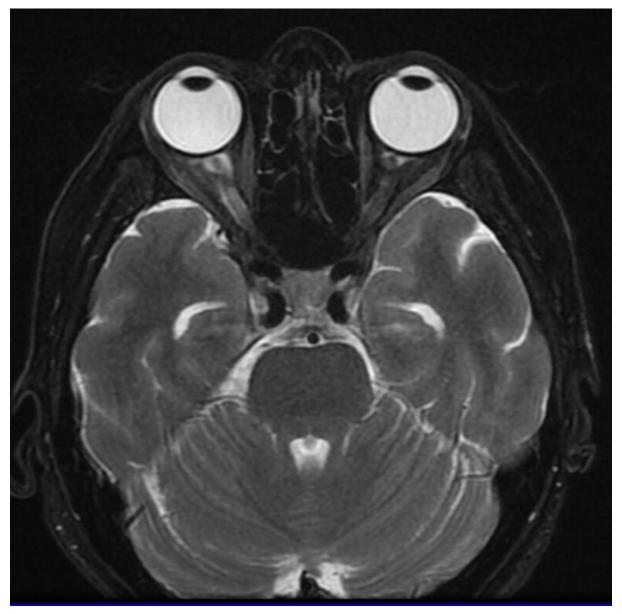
T2-weighted axial brain MRI
